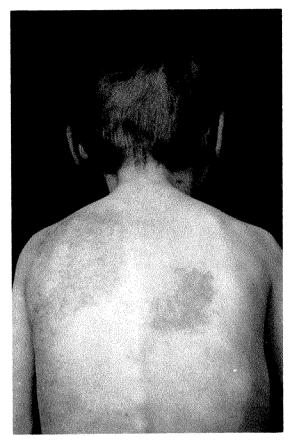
A four year old boy in whom there was reactivation of latent radiation effects in the skin. This child received combined roentgen-ray and actinomycin D therapy for left midlung and right paracardiac metastases. The skin reddened but soon returned to normal. Hepatic metastases became evident three months later, and roentgen-ray treatment of the liver combined with chemotherapy was started. Simultaneously with the administration of actinomycin D, reactions reappeared that coincided in size and distribution with the earlier treatment portals.
